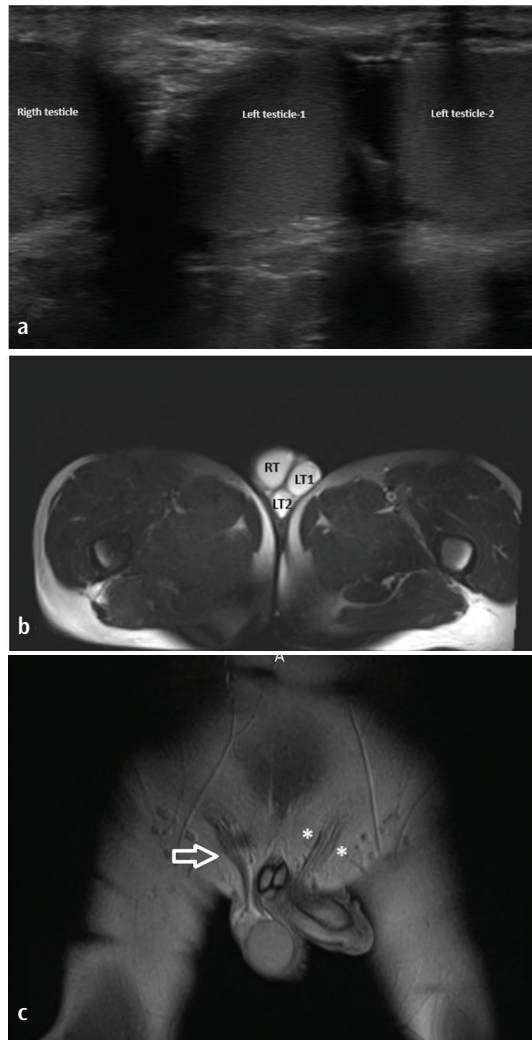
(a) Testicular ultrasound reveals an oval-shaped supernumerary testicle adjacent to the normal testicle in the left scrotum, with similar echogenicity and vascularity to the normal testicle and its epididymis. (b) In the axial T2-weighted pelvic MRI shows an extra testicle adjacent to a normal testicle on the left side of the scrotum. The signal intensities of all three testicles were normal high signal. (c) In the coronal T1-weighted pelvic MRI sequence, each testicle shows its own epididymis and vas deferens (white arrow: right vas deferens, white stars: vas deferens of the left normal and supernumerary testis).
